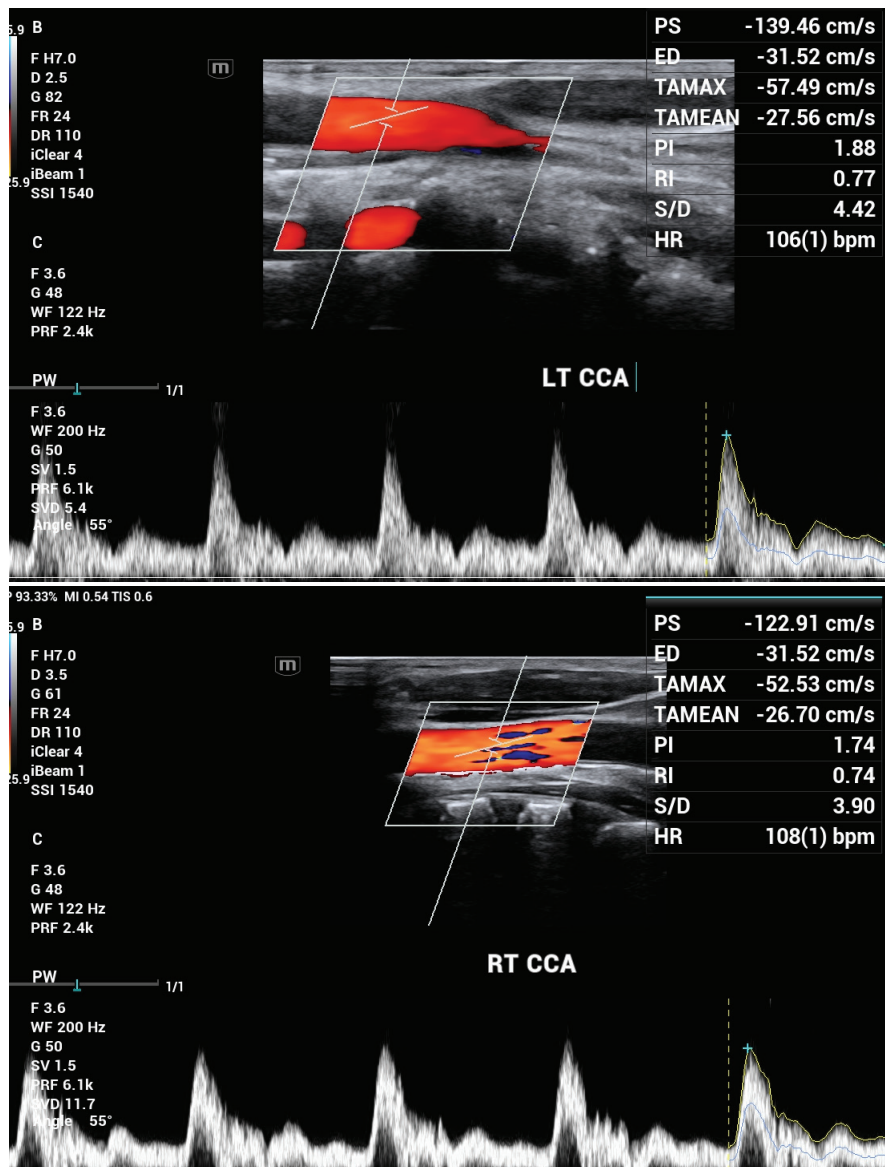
Doppler images show no turbulence.
